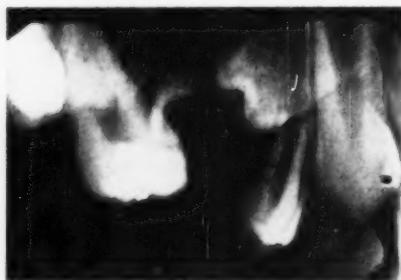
Radiograph showing chaos as a result of retaining an ankylosed deciduous second molar.
